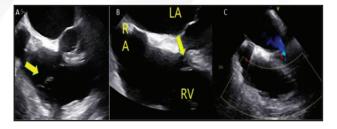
Transesophageal echocardiogram – Mid esophageal 4-Chamber view showed A. 2.36 mm vegetation on the anterior tricuspid valve leaflet B. and on the septal tricuspid valve leaflet. C. Color flow Doppler showed moderate tricuspid regurgitation
